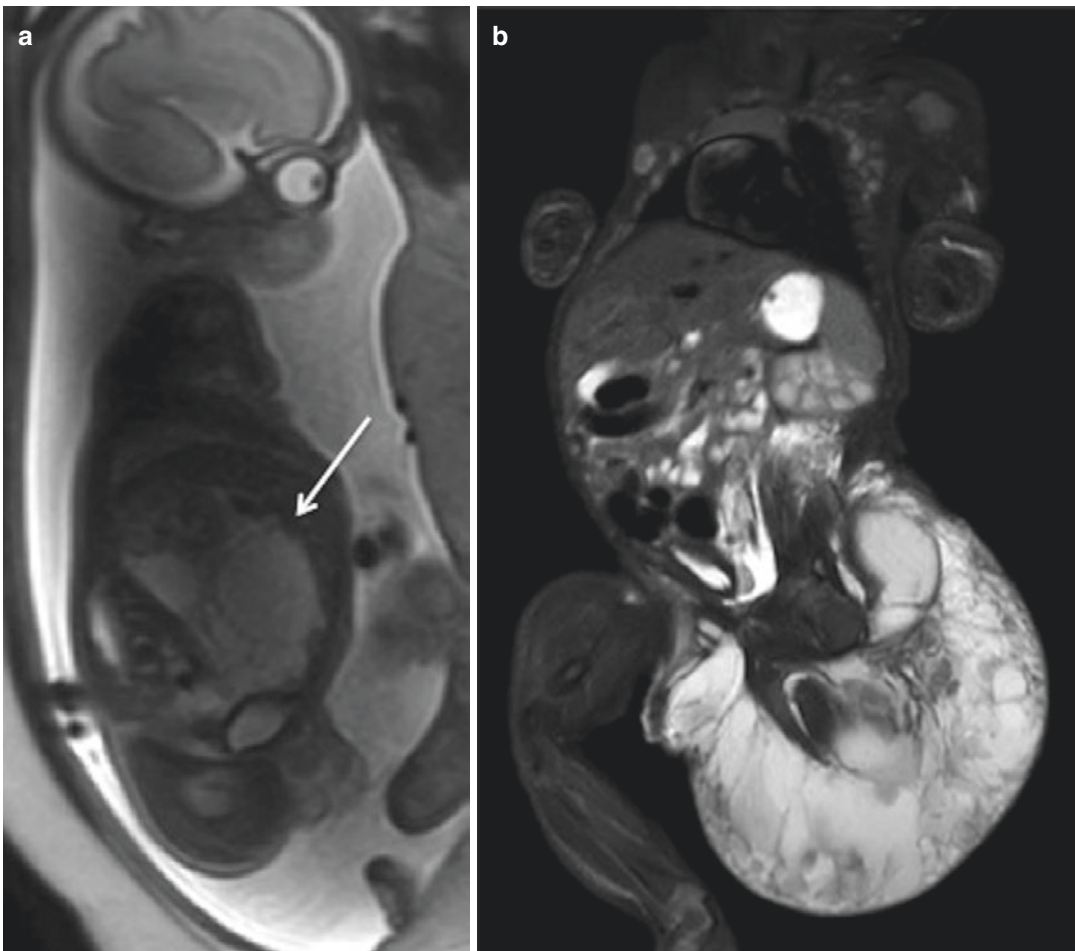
Lymphatic malformation. (a) Sagittal T2 weighted MR image performed on a 29-week-old fetus showing a massive retroperitoneal lymphatic malformation presenting the typical cystic and septated aspect. (b)
